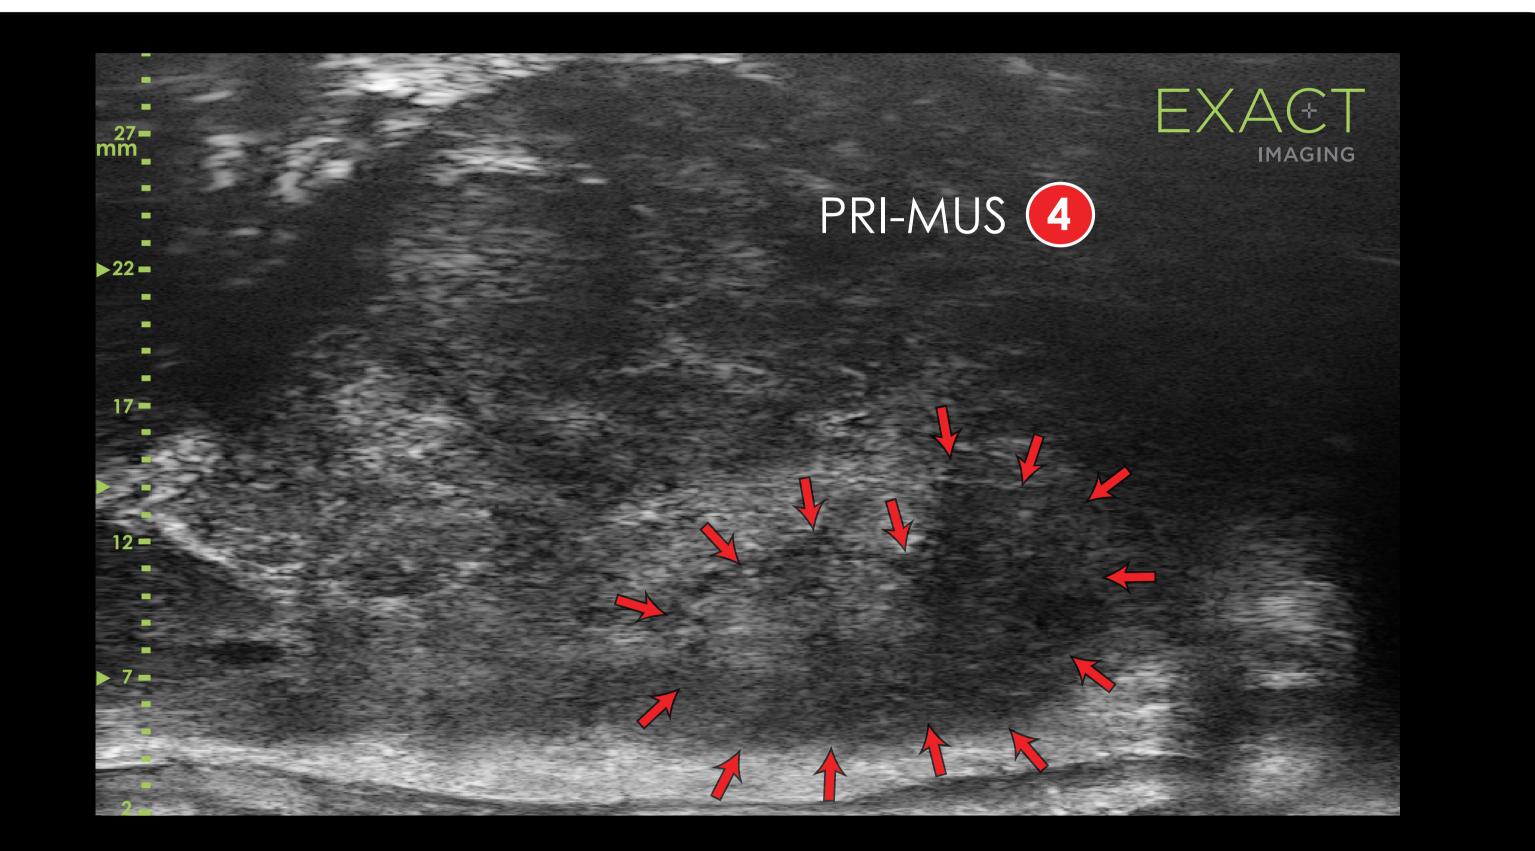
False negative case for micro-ultrasound.
